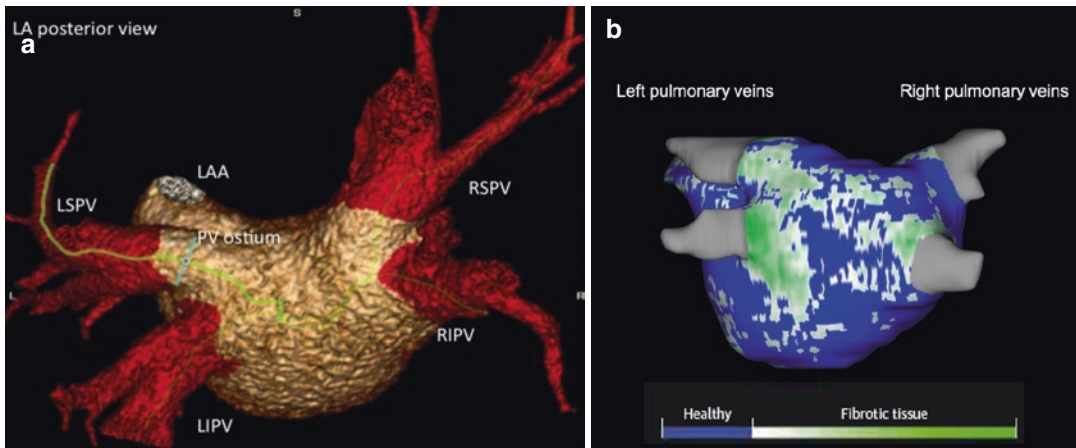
(a) Computed tomography pulmonary vein assessment. LIPV: Left Inferior Pulmonary Vein; LSPV: Left Superior Pulmonary Vein; RIPV: Right Inferior Pulmonary Vein; RSPV: Right Superior Pulmonary Vein;
